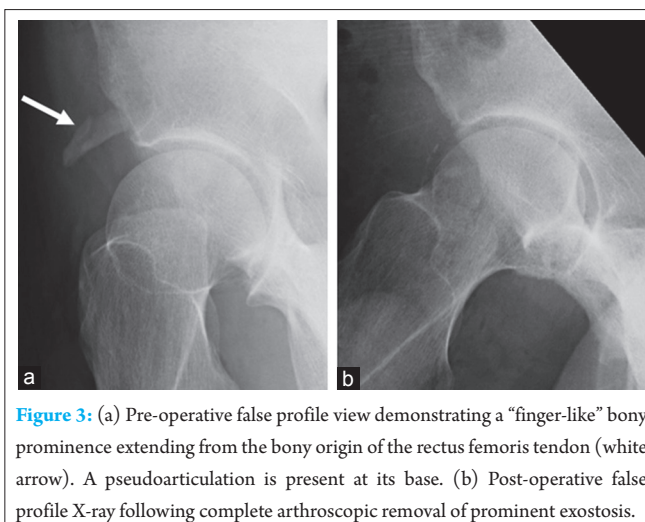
(a) Pre-operative false profile view demonstrating a "finger-like" bony prominence extending from the bony origin of the rectus femoris tendon (white arrow). A pseudoarthrosis is present at its base. (b) Post-operative false profile X-ray following complete arthroscopic removal of prominent exostosis.
